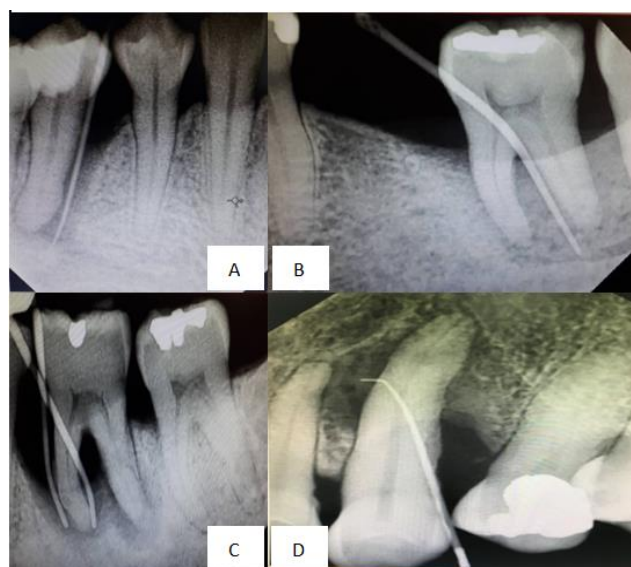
Intraoral Periapical X-Ray Shows GP Size 30 Introduced through the Periodontal Pocket Associated with the Lesion of Periodontal Origin.
